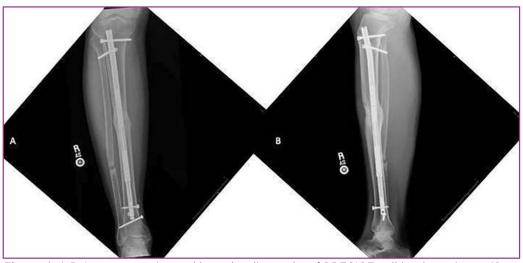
A,*B Anteroposterior and lateral radiographs of PRECICE nail implantation at 12* months follow-up showing union of the tibial osteotomy site and nonunion of the fibula.
